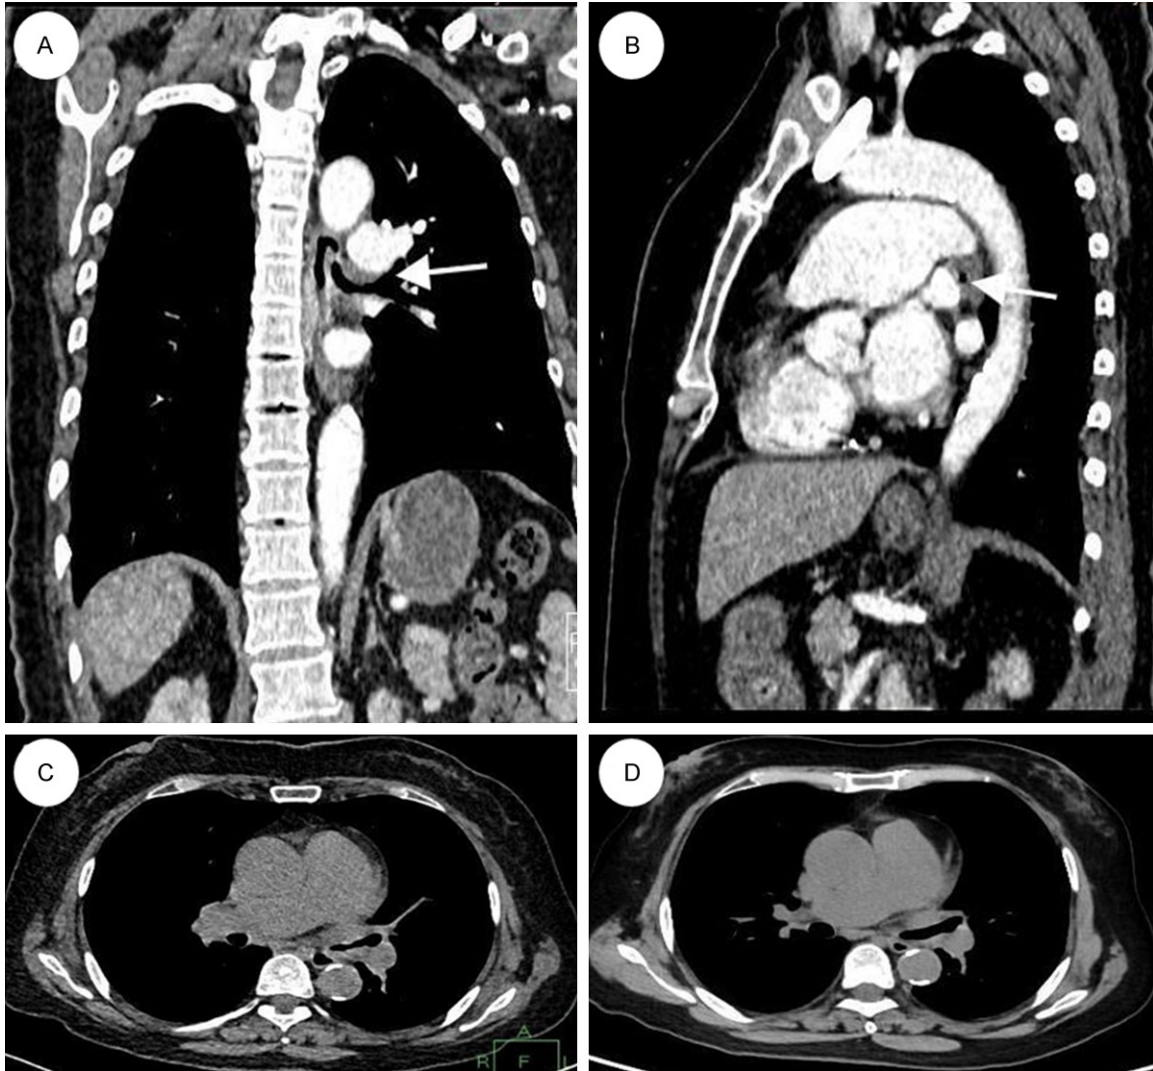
Chest contrast-enhanced computed tomography (CT) scans of a 64-year-old female patient with tracheo-bronchial amyloidosis (TBA) associated with Sjögren's syndrome (SS) and type 2 diabetes mellitus (T2DM). A: Coronal reconstruction at admission demonstrating irregular circumferential thickening of the airway wall involving the trachea and left main bronchus (white arrow) with associated luminal narrowing. B: Axial view at the level of the carina showing severe stenosis of the distal left main bronchus (approximately 70% reduction in diameter) and soft tissue nodular shadows obstructing the proximal segments of the upper and lower lobar bronchi (white arrow). C: Initial presentation at admission: irregular circumferential thickening of the left main bronchus wall with severe luminal narrowing and nodular soft tissue densities obstructing the bronchial tree. D: Three-month follow-up contrast-enhanced CT scan showing significant improvement with reduced airway wall thickness, restored luminal patency (>80% recovery in diameter), and resolution of previously observed nodular shadows. No new lesions or progression of stenosis was evident; the patient remained asymptomatic with stable disease status. CT parameters: 256-slice multidetector CT, slice thickness 1.0 mm, intravenous contrast enhancement (100 mL iodinated contrast, 30-second delay).
